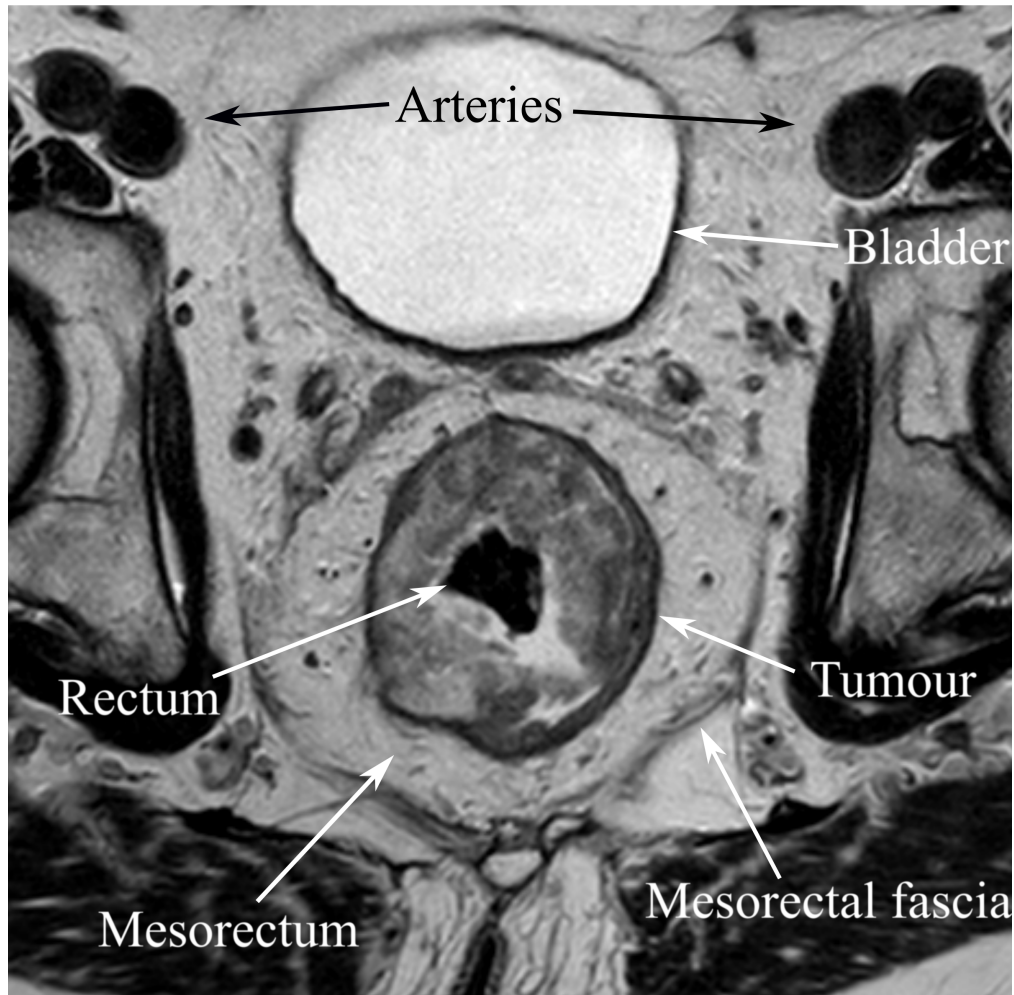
A T_2 -weighted MR image of the axial plane of the pelvic area and rectum, acquired using a fast spin echo sequence. The T_2 -weighting causes the fatty tissue to appear bright due to its long relaxation time, and the tissue with high concentrations of water to appear dark. Arrows indicate the tumour, mesorectum, mesorectal fascia, rectum, bladder and four artery cross sections. The image shows a patient from the Oxytarget study.
